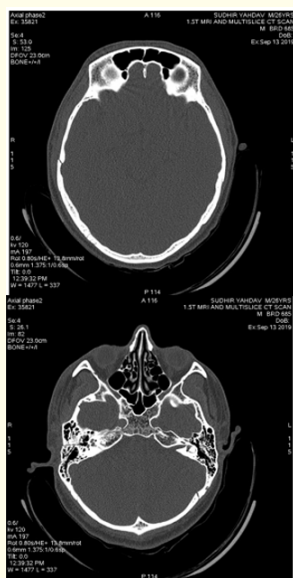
(a): CT head and MRI of the same patient showing fracture of squamous part of right temporal bone extending to the petrous part of the right temporal bone.
